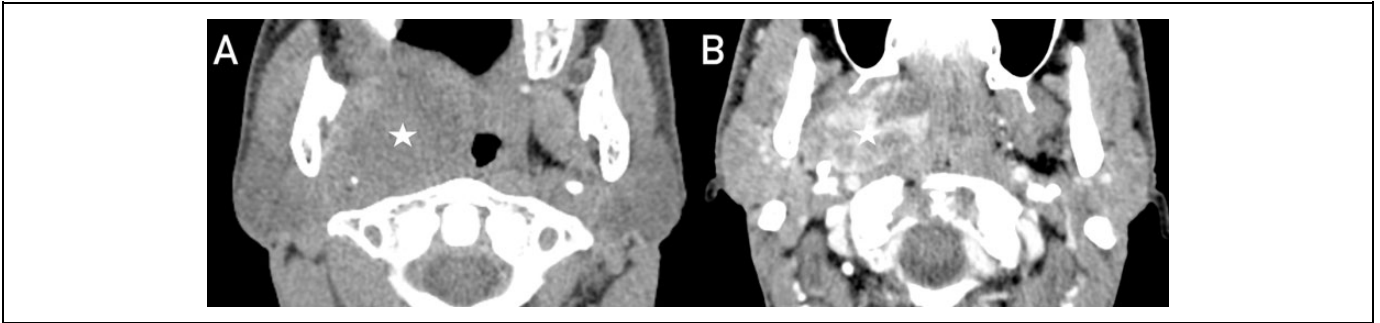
Computed tomography (CT), axial planes, pre- (A) and postcontrast (B) images showing an ovoidal mass (star) located in the right parapharyngeal space, characterized by sharp borders and causing fat obliteration with compression and narrowing of the rhino-oropharynx air column. The mass had a density similar to the parotid gland and little lower than muscles and was characterized by a heterogenous early enhancement on postcontrast scans (B).
